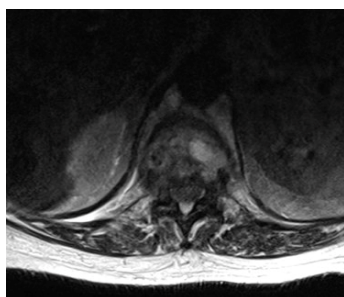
Preoperative axial T2 weighted Magnetic Resonance Imaging (MRI) at the level of the T12 vertebra revealing a destructive lesion of the T12 vertebral body and an epidural abscess causing spinal cord compression
